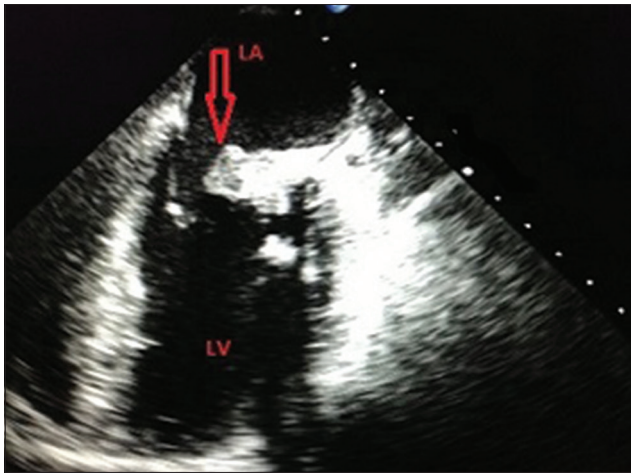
Transesophageal echocardiogram shows mitral valve mass (arrows). LV: Left ventricle, LA: Left atrium
